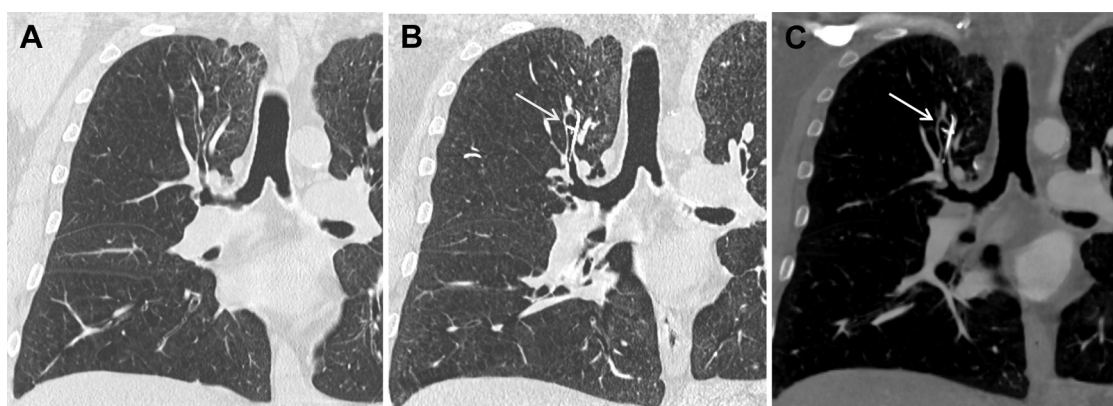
Unenhanced chest CT scan in the coronal plane through the right upper lobe bronchus, which shows mild irregularities of apical segmental bronchus lumen before insertion of endobronchial coils (A). Three and a half years after endobronchial coils insertion, moderate focal bronchiectasis is seen at the site of one of the coils (arrow), whose proximal tip is in the dilated bronchus in pulmonary window (B) and mediastinal window (C).
